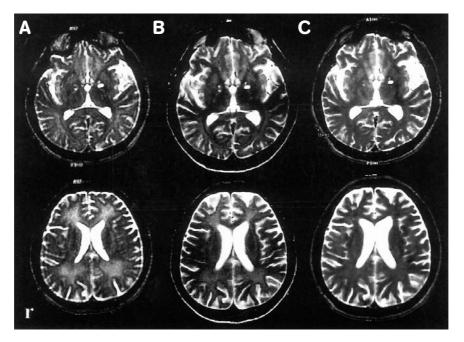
Serial brain MRI studies revealed a steady improvement in the subcortical white matter and to a lesser degree of improvement in the globus pallidum in patient 10. (A: at 2 months B: at 5 months, C: at 1 year)
